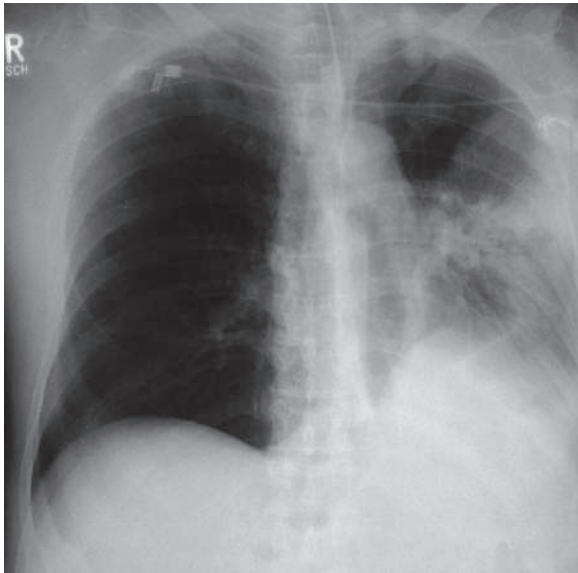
Anteroposterior plain chest radiograph of a bedridden patient shows mediastinal shift toward the left side due to collapse of the left lung
